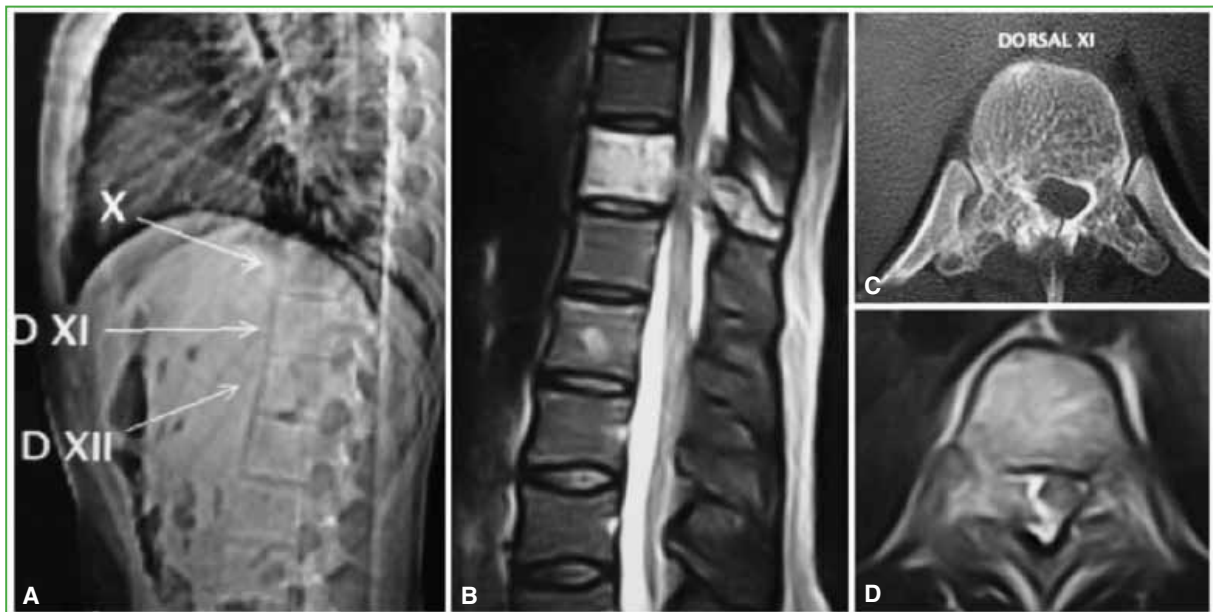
Case 2. A 23-year-old woman. A. Lateral radiograph of the thoracic spine with marking of the level involved without relevant findings. MRI. B. Sagittal plane, T2-weighted sequence. Hyperintensity of the vertebral body is observed, with extension towards the right pedicle and invasion of the medullary canal, displacing the marrow to the left (D). C. Computed tomography, axial plane. The alteration of the bone structure in the vertebral body is observed, with insufflation of the right components of the apophyseal ring.
